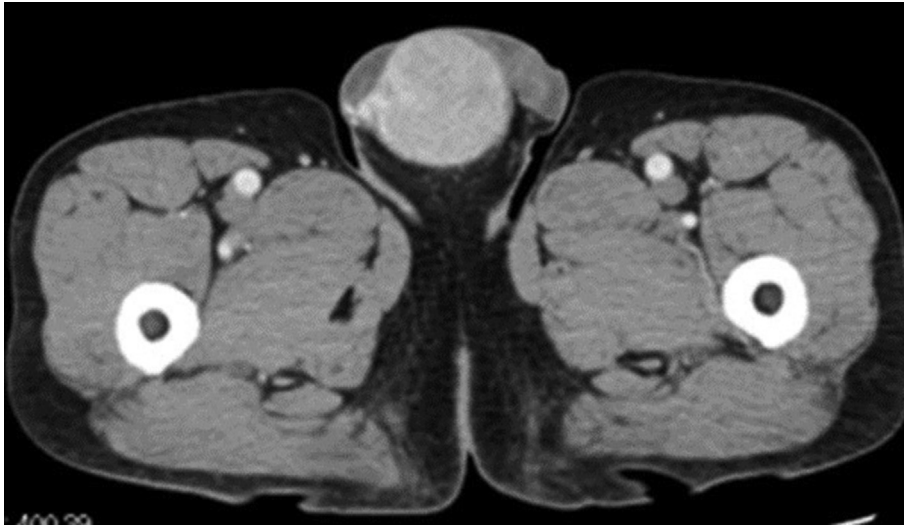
Contrast-enhanced computed tomography revealed a right testicular tumor of 5.4 cm diameter with heterogeneous enhancement. No lymph-node or distant metastasis was observed.
